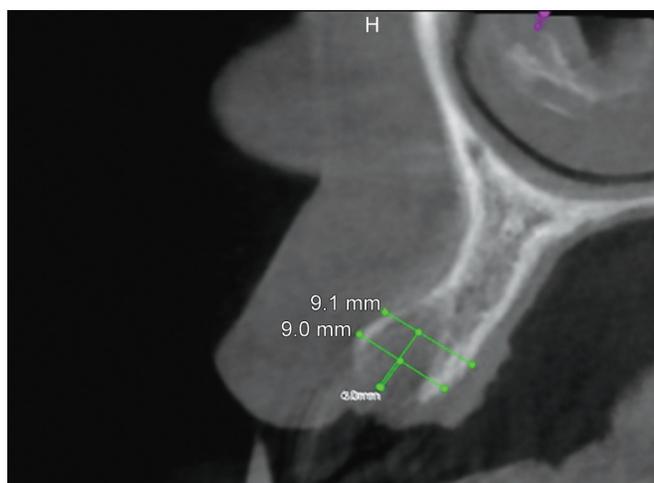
CBCT evaluation of the alveolar ridge dimensions at Point 1 and Point 2
